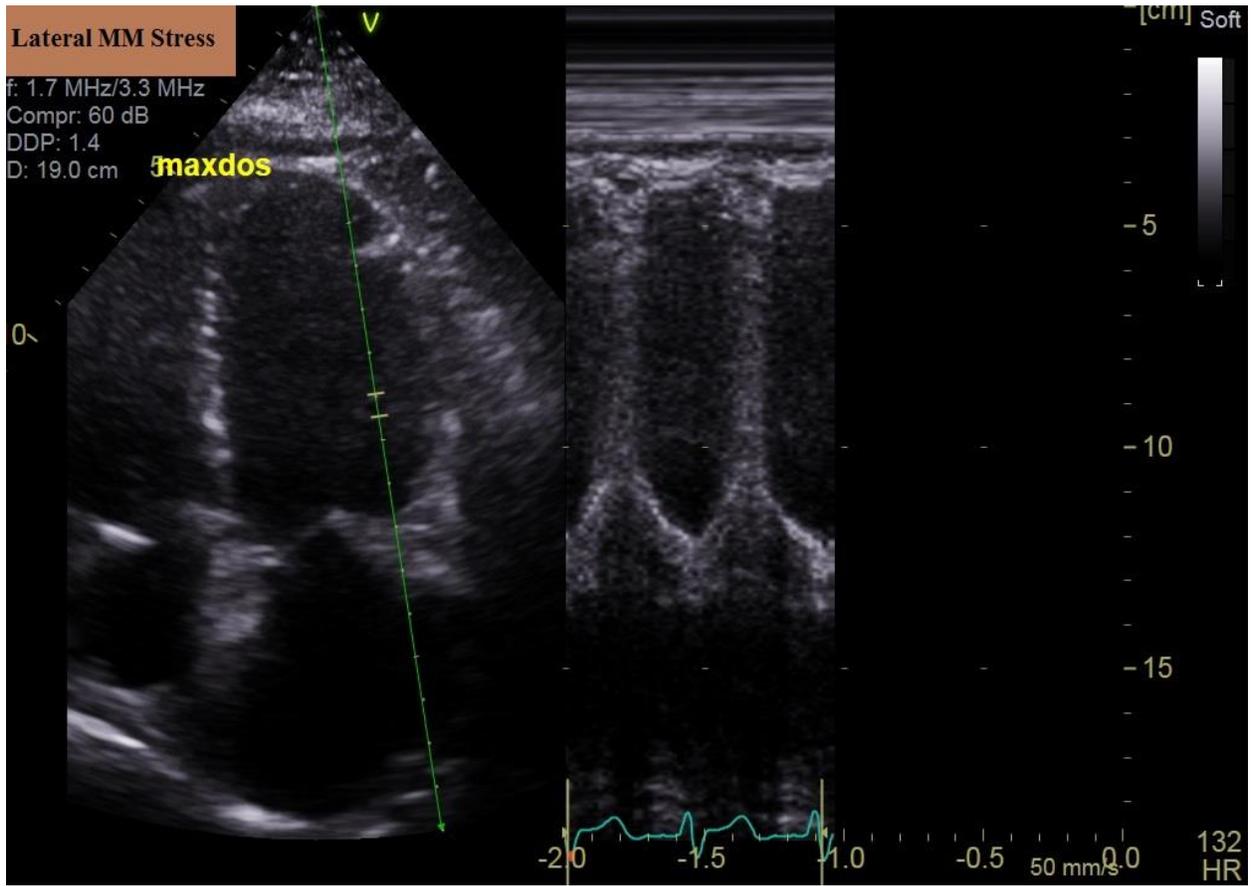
Trans-thoracic echocardiography, Lateral M-mode at peak stress.
